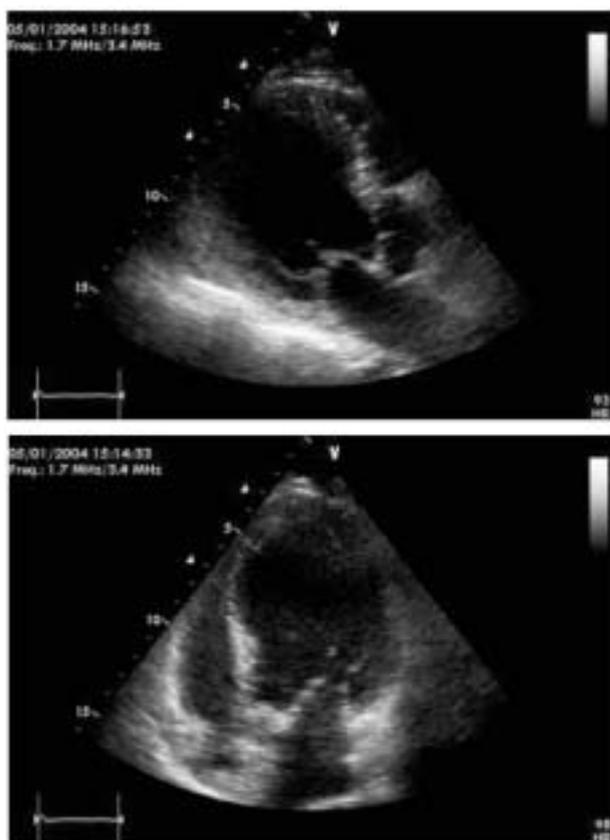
Echocardiographic findings on 2 January 2004. LVEDV=183 mL, LVESV=136 mL, end-diastolic diameter [DTD]=7.46 cm, end-systolic diameter [DTS]=5.64 cm, ejection fraction 31.7%, E-septum (distance between E point and septum in M-mode)=1.8 cm, left atrial area=23 cm<sup>2</sup>, wall motion score index=1.5.
